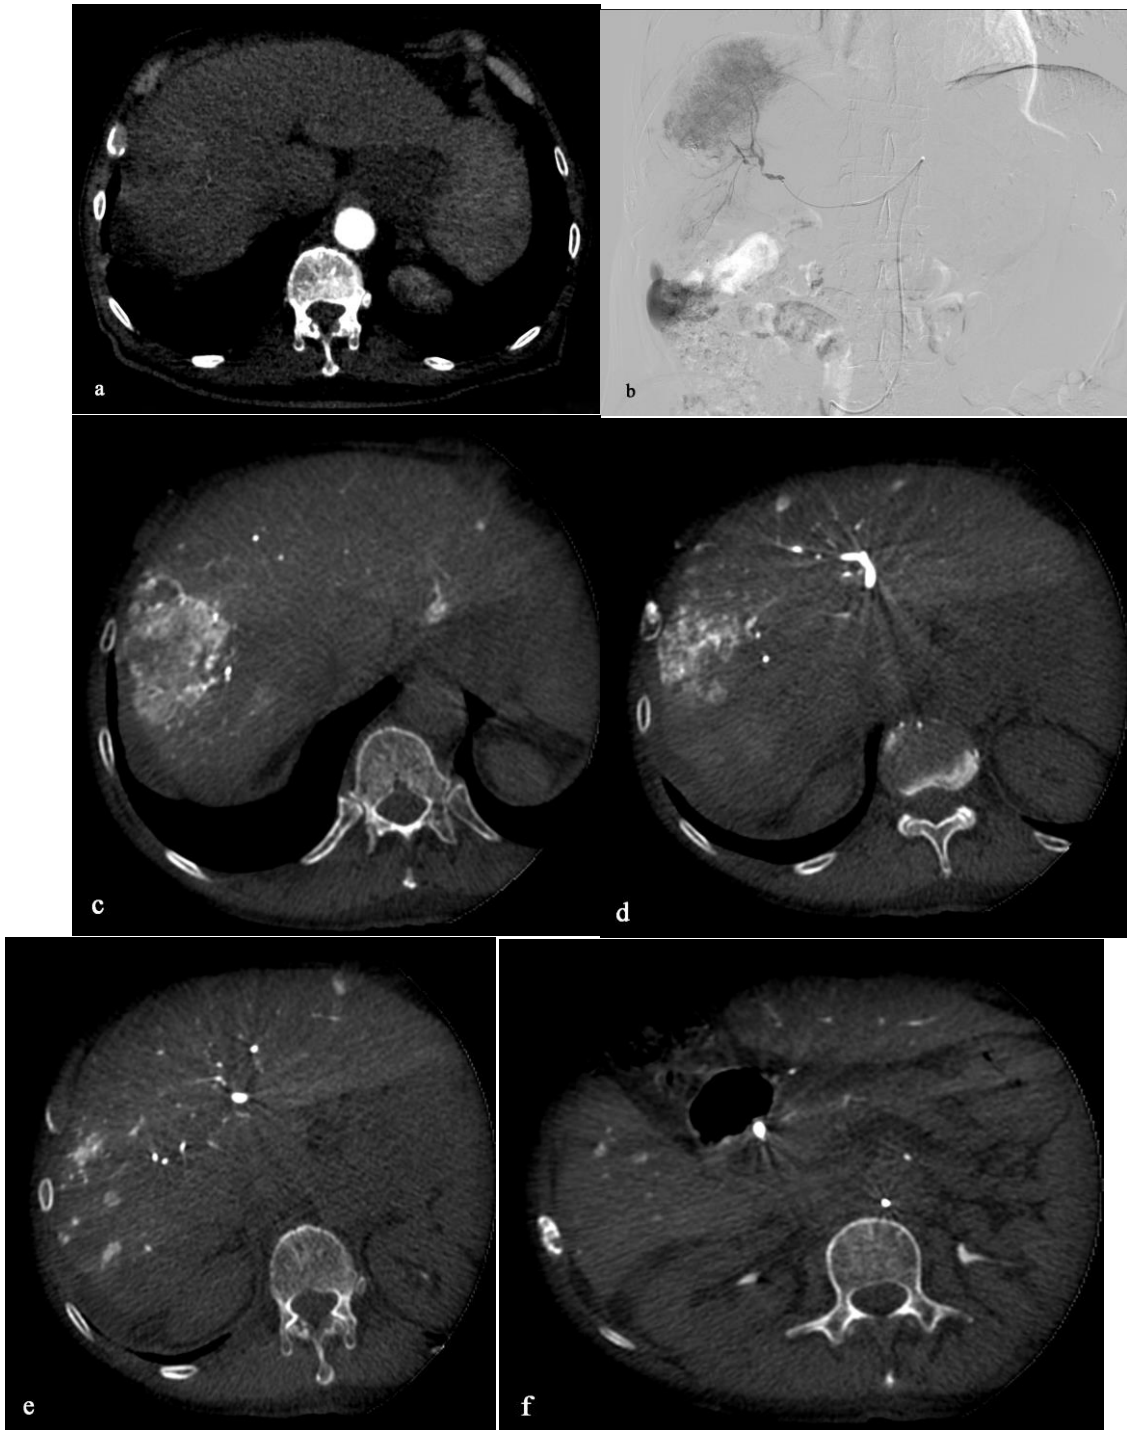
a) preimagingCT:faintly enhancing tumor in the right lobe of the liver (segment VIII), b) DSA: the tumor seen in the right lobe, c:f) CBCT: the tumor in the right lobe clearly seen at segment VIII, Other additional tumors seen in segment II, III V and VI
